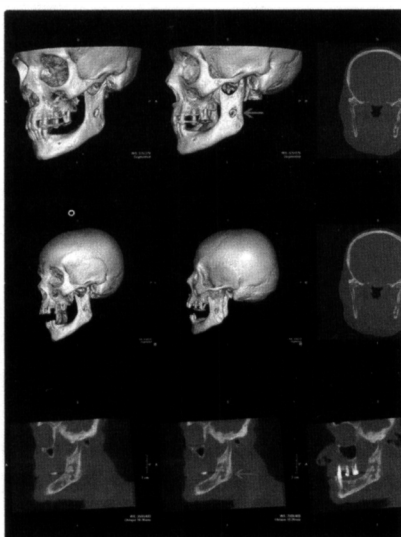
A no dentascan jaw CT (3D-reconstruction) shows sclerosis of the left mandible with areas of cortical erosion both internally and externally
